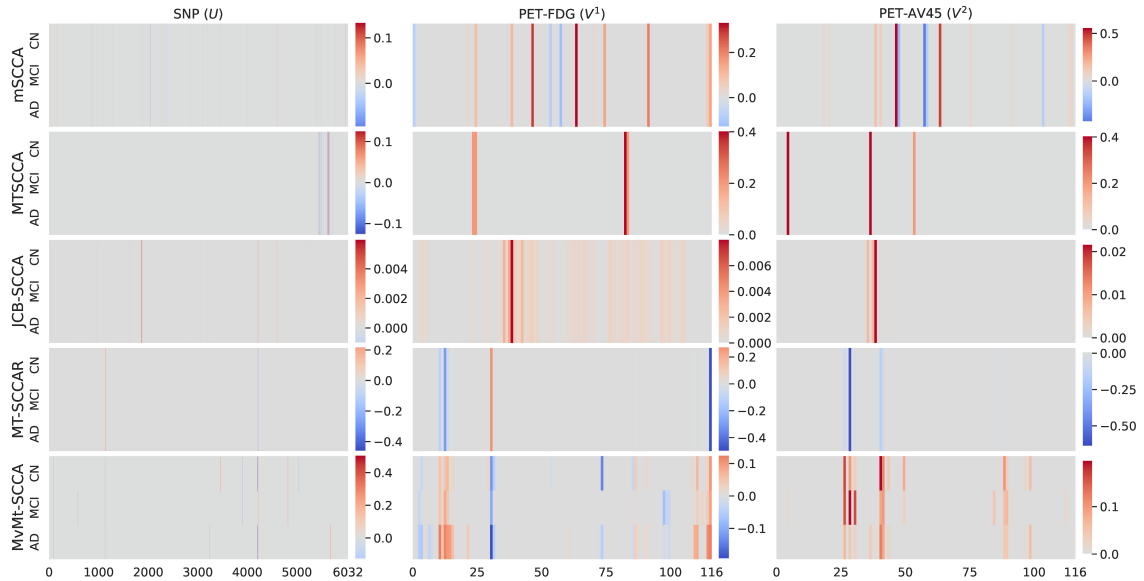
Mean canonical weights of SNPs (U : 1st column), PET-FDG (V^1 : 2nd column) and PET-AV45 (V^2 : 3rd column) obtained over five-fold cross-validation.
